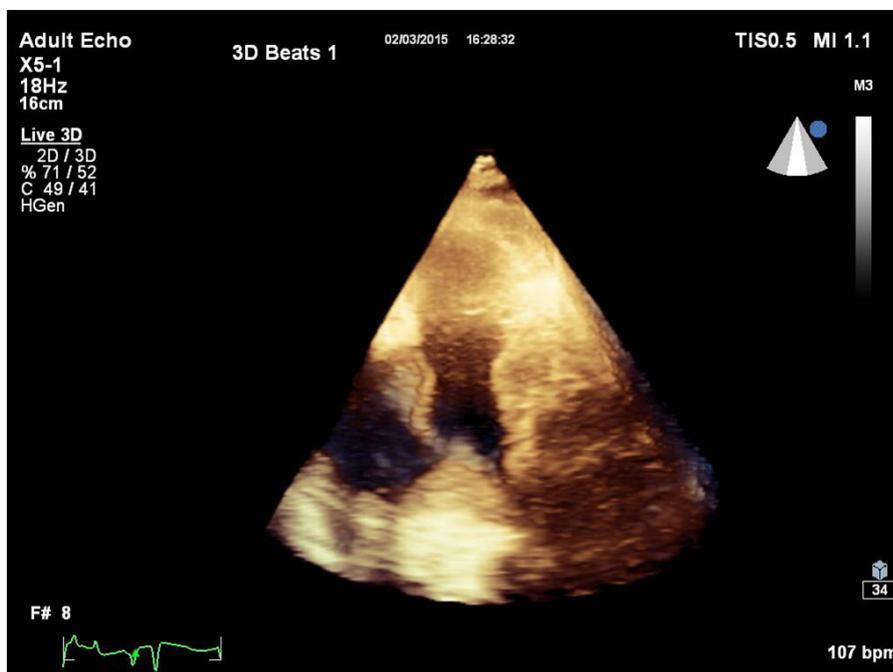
3 dimensional Echocardiographic Parasternal short axis view (PSAX) shows a saddle thrombus at the Main Pulmonary artery bifurcation extending into its two branches.
